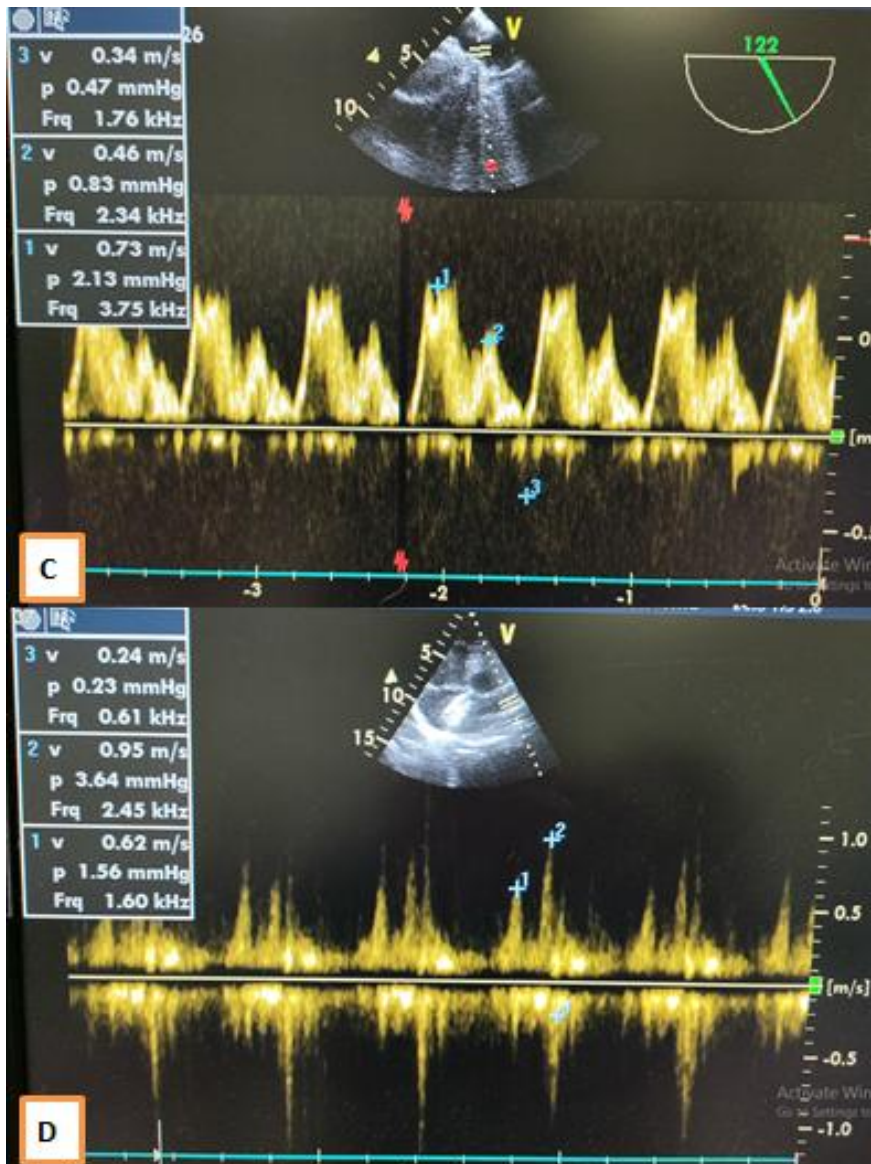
Pulmonary venous flow Doppler by trans-esophageal (C) and transthoracic (D) echocardiography of the same patient after successful closure of ASDII, showed immediate splitting of the antegrade wave after closure and increase in AR wave (C) with further improvement 3 months post procedure (D)
